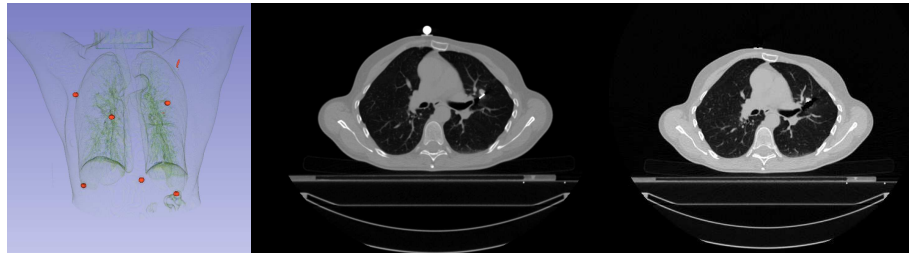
Example of patient 3D image data. On the left we show a volume rendering of the dataset where the chest markers are very well visible. On the center we show a slice of the CT where both one of the chest markers and the gold marker (on the left lung, right side of the image) are visible. On the right, we show the same slice with the chest and gold markers removed. This last dataset was used for DRR generation.
